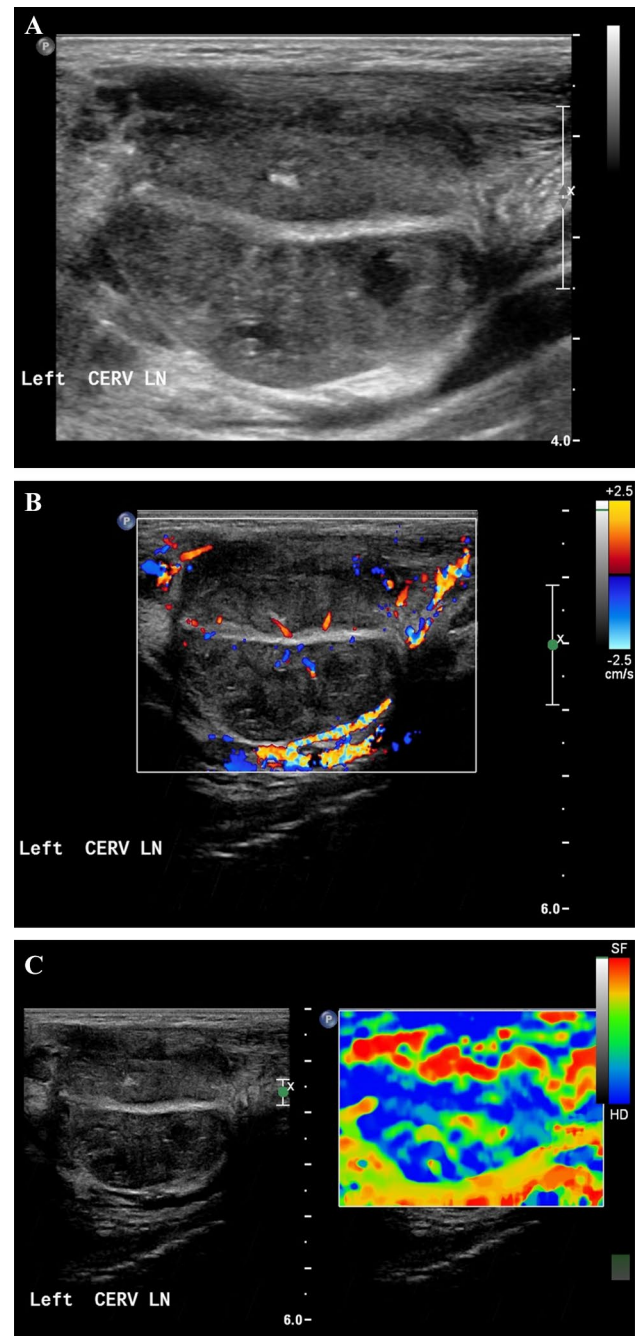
a B-Mode US of an enlarged cervical lymph node with loss hyperechoic hilum, markedly thickened hypoechoic cortex suggestive of malignancy. b Color Doppler US of a malignant LN showing markedly increased peripheral and central vascularity. c Elastographic US of a malignant LN shows large blue area(s); total blue area $\geq 45\%$ indicate increased hardness with strain ratio: 6.5
